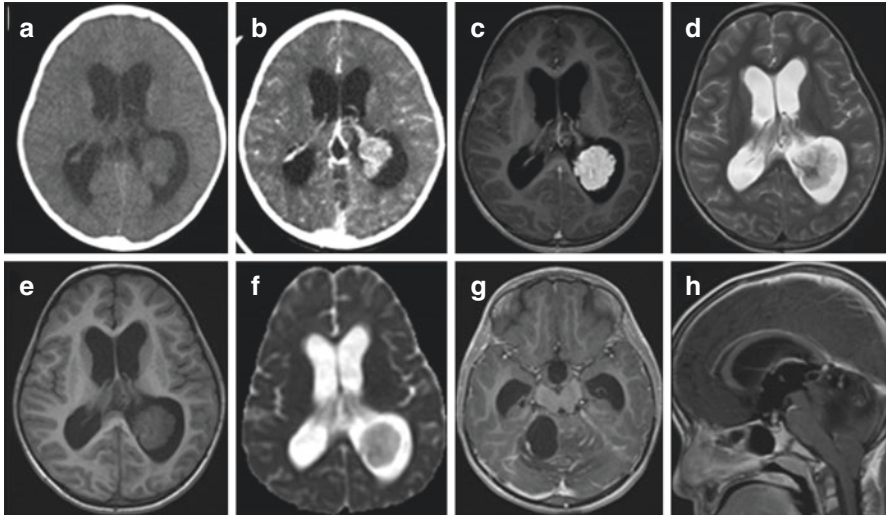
Neuroimaging of a typical Choroid Plexus Papilloma. (Patient example from our own institution, Neurosurgical Service, KK Women's and Children's Hospital). Well-demarcated, intra-ventricular lesion in the atrium of the left lateral ventricle with a cauliflower appearance seen with intense homogeneous enhancement suggestive of a choroid plexus papilloma. Despite the low-grade nature of this lesion, there is dissemination along the CSF pathways with a solid-cystic lesion in the right cerebellar hemisphere and pituitary stalk, highlighting the importance of imaging of the entire neuroaxis. (a and b): Axial plain and contrasted CT image; (c–f) Axial T1W + C, T2W image, T1W image, ADC image at the level of ventricular atrium respectively; (g) Axial T1W + C image at the level of midbrain; (h) Sagittal T1W + C image (CSF: cerebrospinal fluid; CT: computed tomography; T1W + C: T1 weighted with contrast; ADC: apparent diffusion coefficient)
